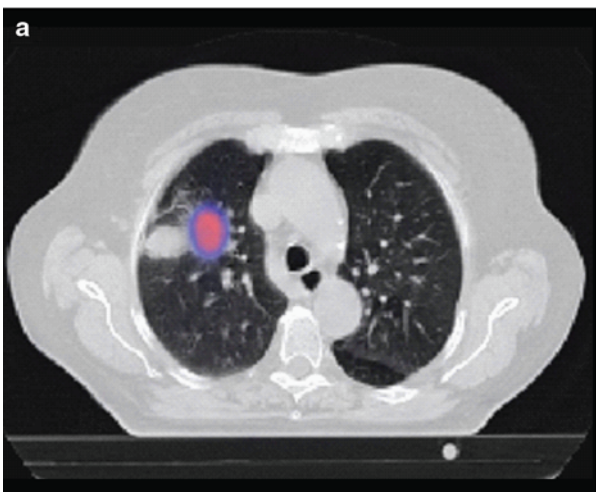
Combination of PET and CT scans using fusion techniques. The CT and PET are made on the same time and corrected for anatomical variation in position of the patient. The axial and coronal images show a
